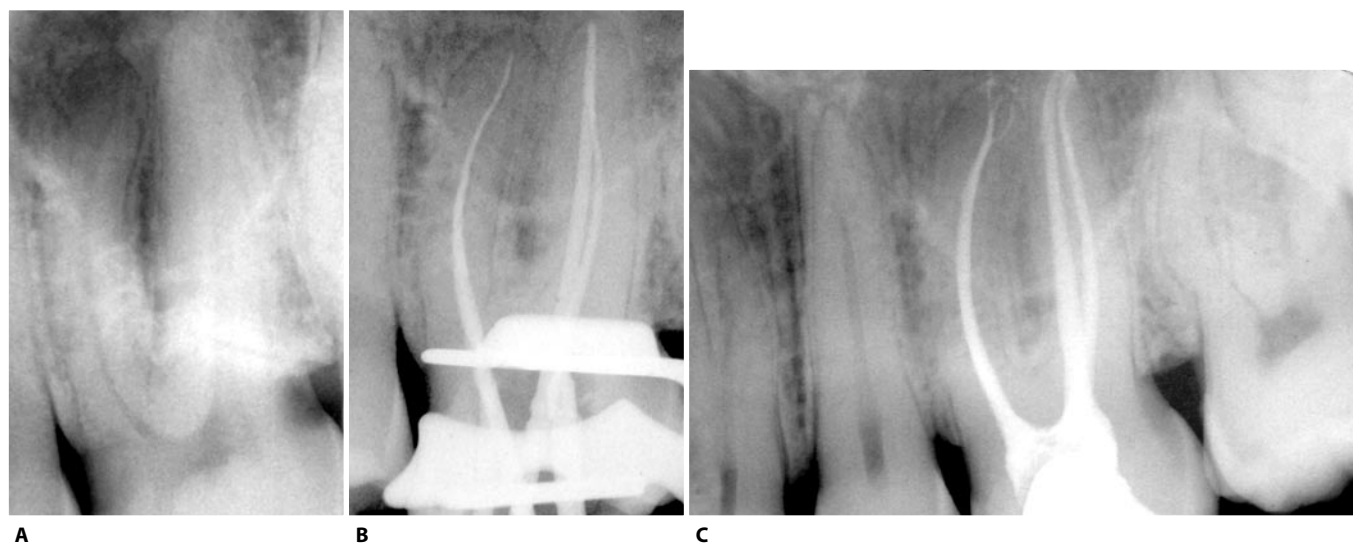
A. Endodontic treatment of an upper left first molar with particularly long roots (26 mm). B. Radiograph with verifiers. C. Post-operative radiograph. Note the complex apical anatomy in the mesial root perfectly filled with Thermafil gutta-percha.
